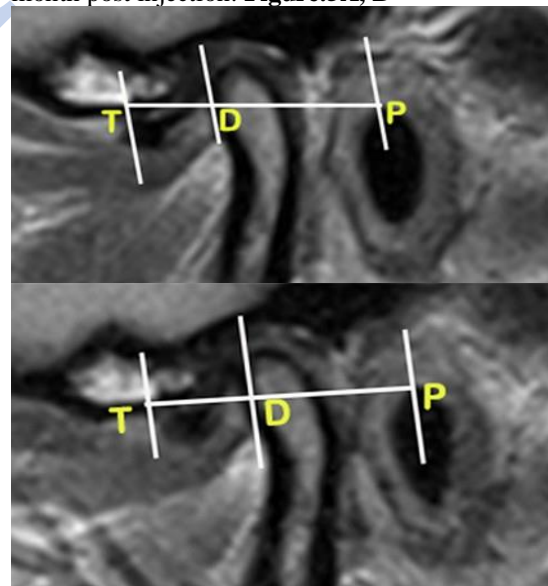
A, disc position in preoperative MRI. B, improvement in disc position in post operative MRI.
